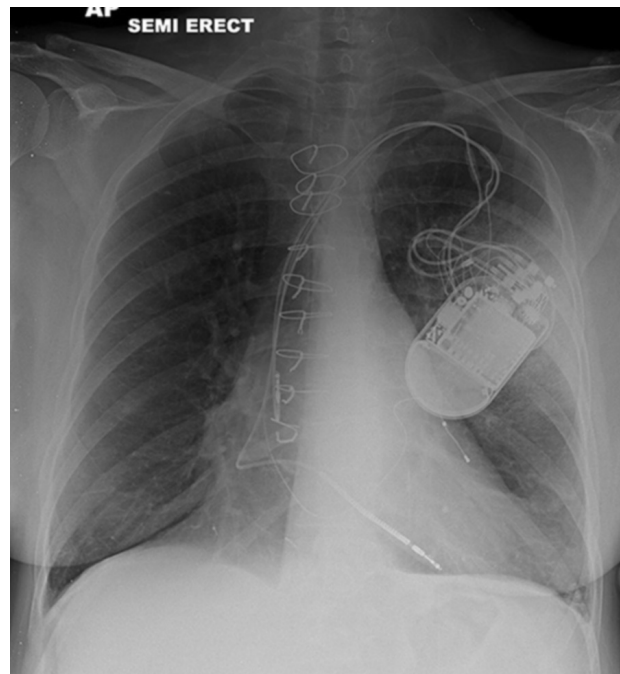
A 56-year-old woman with fever and cough. The AP chest radiograph shows an implanted cardioverter-defibrillator over the left chest, largely obscuring a vague left lung opacity.
